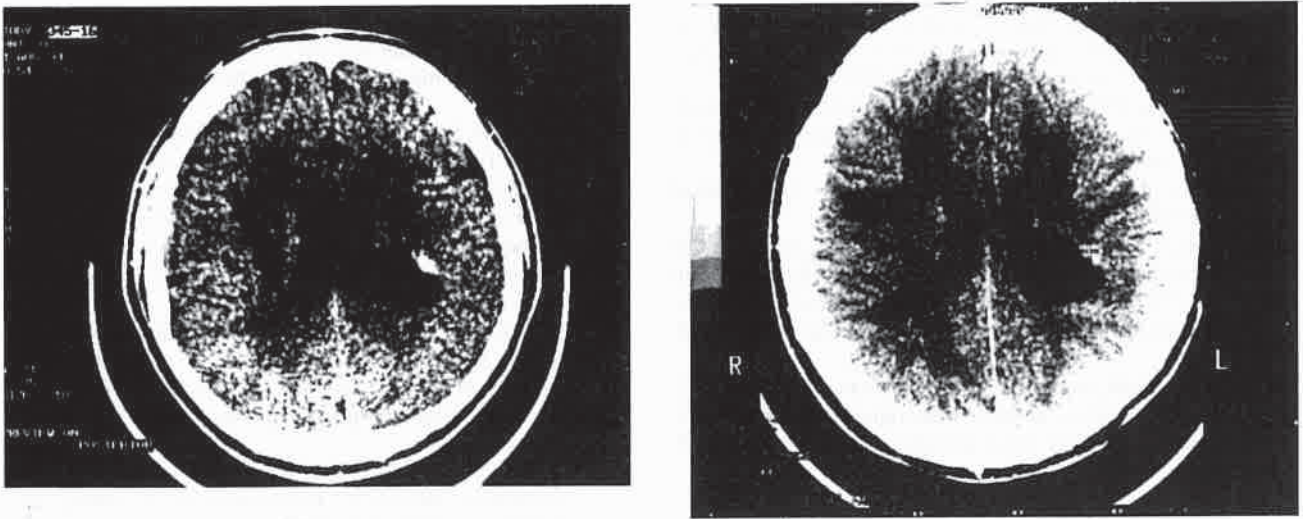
CT scan without contrast media (Fig 5A) and with contrast media (Fig 5B) revealed a hyperdense lesion extending into the lateral ventricle.
